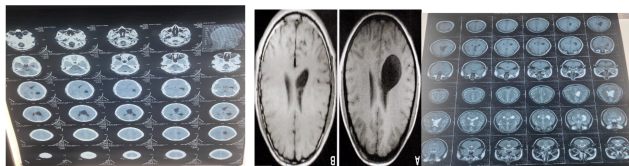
Radiographic images
